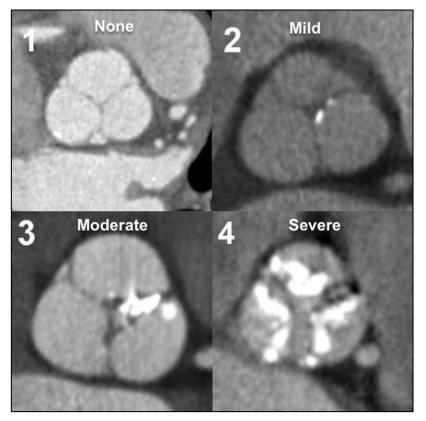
Evaluation of the aortic valve calcification by computed tomography
